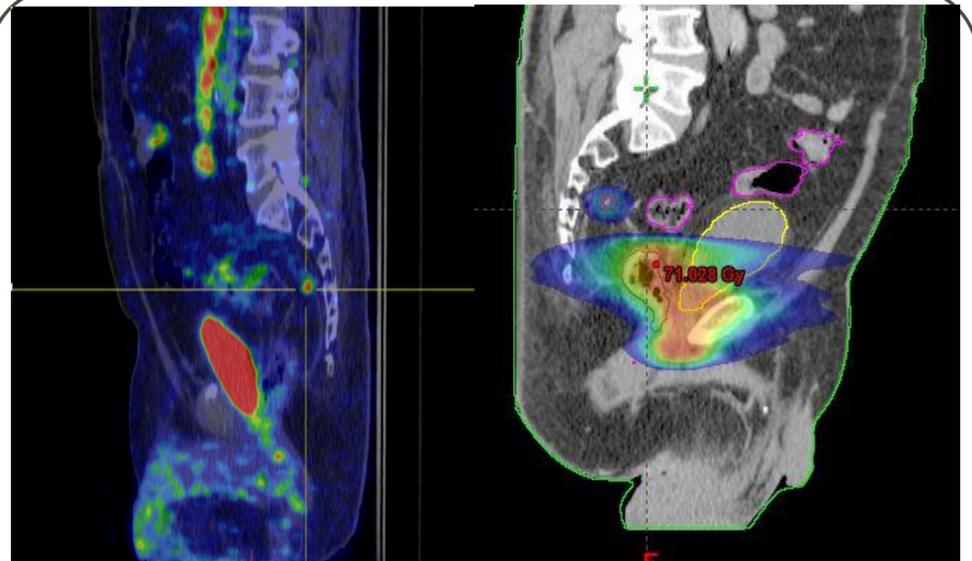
⁶⁸Ga-PSMA PET/CT Sagittal
